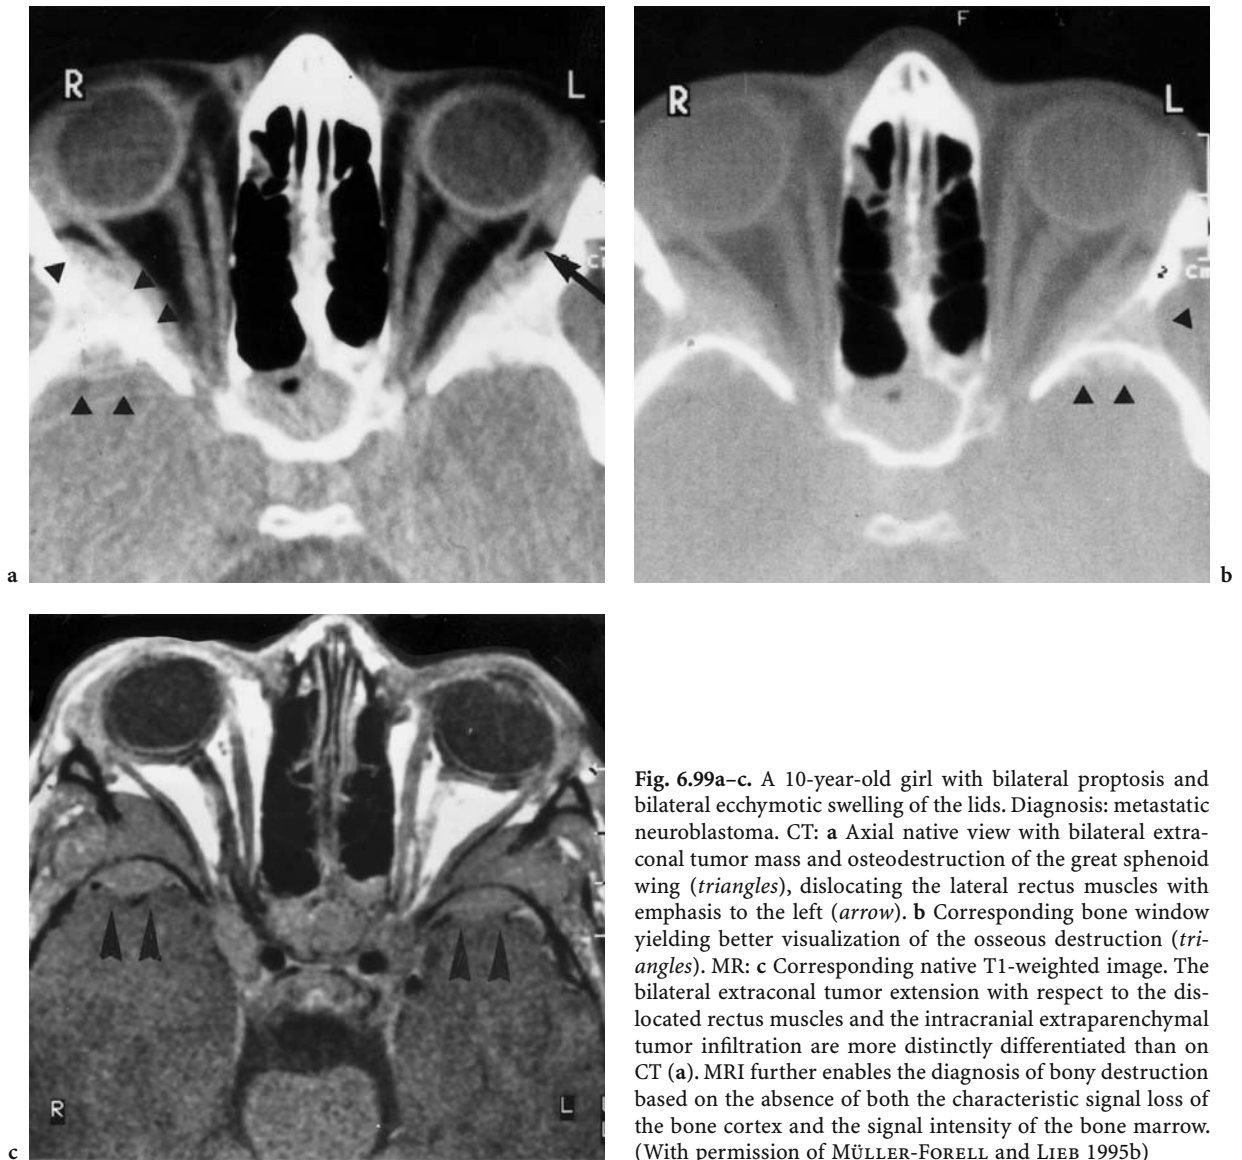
A 10-year-old girl with bilateral proptosis and bilateral ecchymotic swelling of the lids. Diagnosis: metastatic neuroblastoma. CT: a Axial native view with bilateral extraconal tumor mass and osteodestruction of the great sphenoid wing (*triangles*), dislocating the lateral rectus muscles with emphasis to the left (*arrow*). b Corresponding bone window yielding better visualization of the osseous destruction (*triangles*). MR: c Corresponding native T1-weighted image. The bilateral extraconal tumor extension with respect to the dislocated rectus muscles and the intracranial extraparenchymal tumor infiltration are more distinctly differentiated than on CT (a). MRI further enables the diagnosis of bony destruction based on the absence of both the characteristic signal loss of the bone cortex and the signal intensity of the bone marrow. (With permission of MÜLLER-FORELL and LIEB 1995b)
